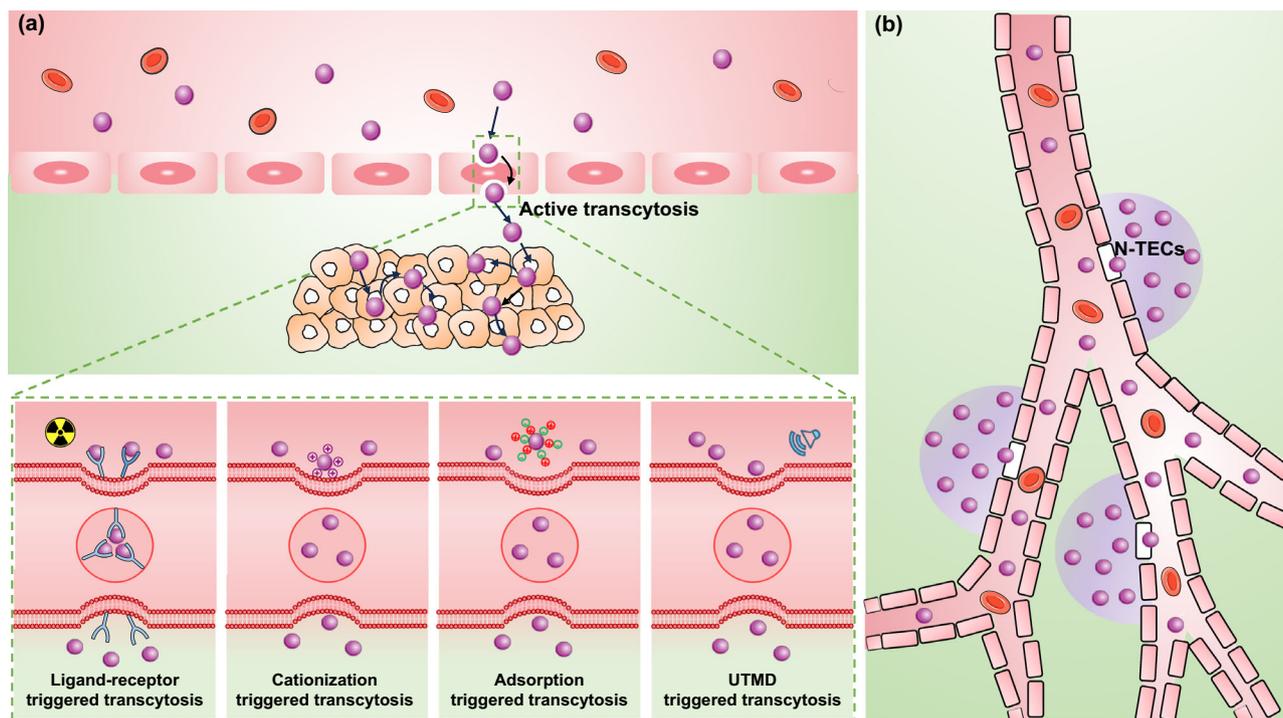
Mechanism and heterogeneity of active transcytosis. a Strategies for enhancing active transcytosis to facilitate the vascular extravasation of NCs, involving ligand-receptor triggered transcytosis (irradiation for precise regulation of receptor expression on endothelial cells), cationization triggered transcytosis, adsorption triggered transcytosis, and ultrasonic targeted microbubble
